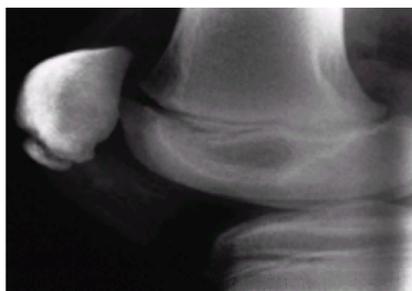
Sinding-Larsen-Johansson disease. The lateral radiograph best demonstrates the irregularity at the inferior pole of the patella.
